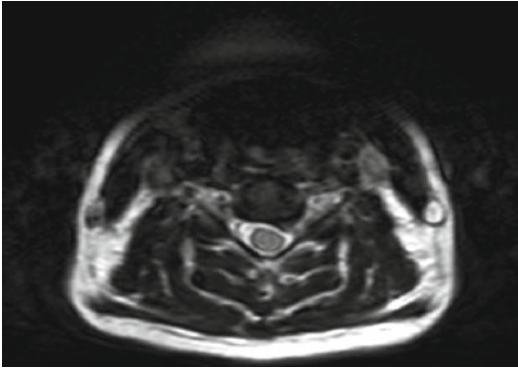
Axial T2-weighted magnetic resonance imaging scan showing left posterolateral soft disk herniation compressing of the exiting root
